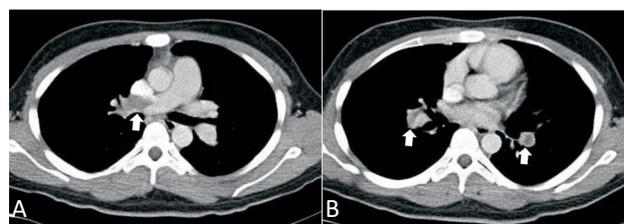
Computed tomography of the chest revealed filling defects over bilateral pulmonary arteries (white arrow).
